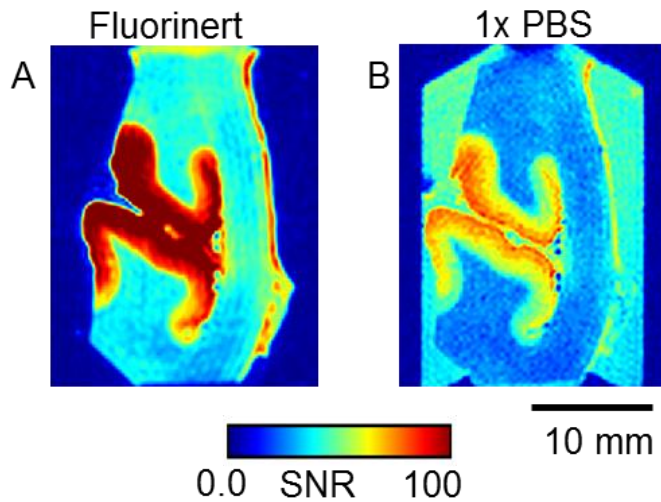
Effects of protonation on signal quality. A. The signal to noise ratio (SNR) of the spin echo images was tested while *ex vivo* tissue was stored in Fluorinert. MRI data collected of tissue stored in Fluorinert showed 20-30% higher SNR than tissue stored in 1xPBS. B. Tissues imaged in 1xPBS had high signal artifact due to the highly protonated nature of PBS, as opposed to magnetically inert Fluorinert.
